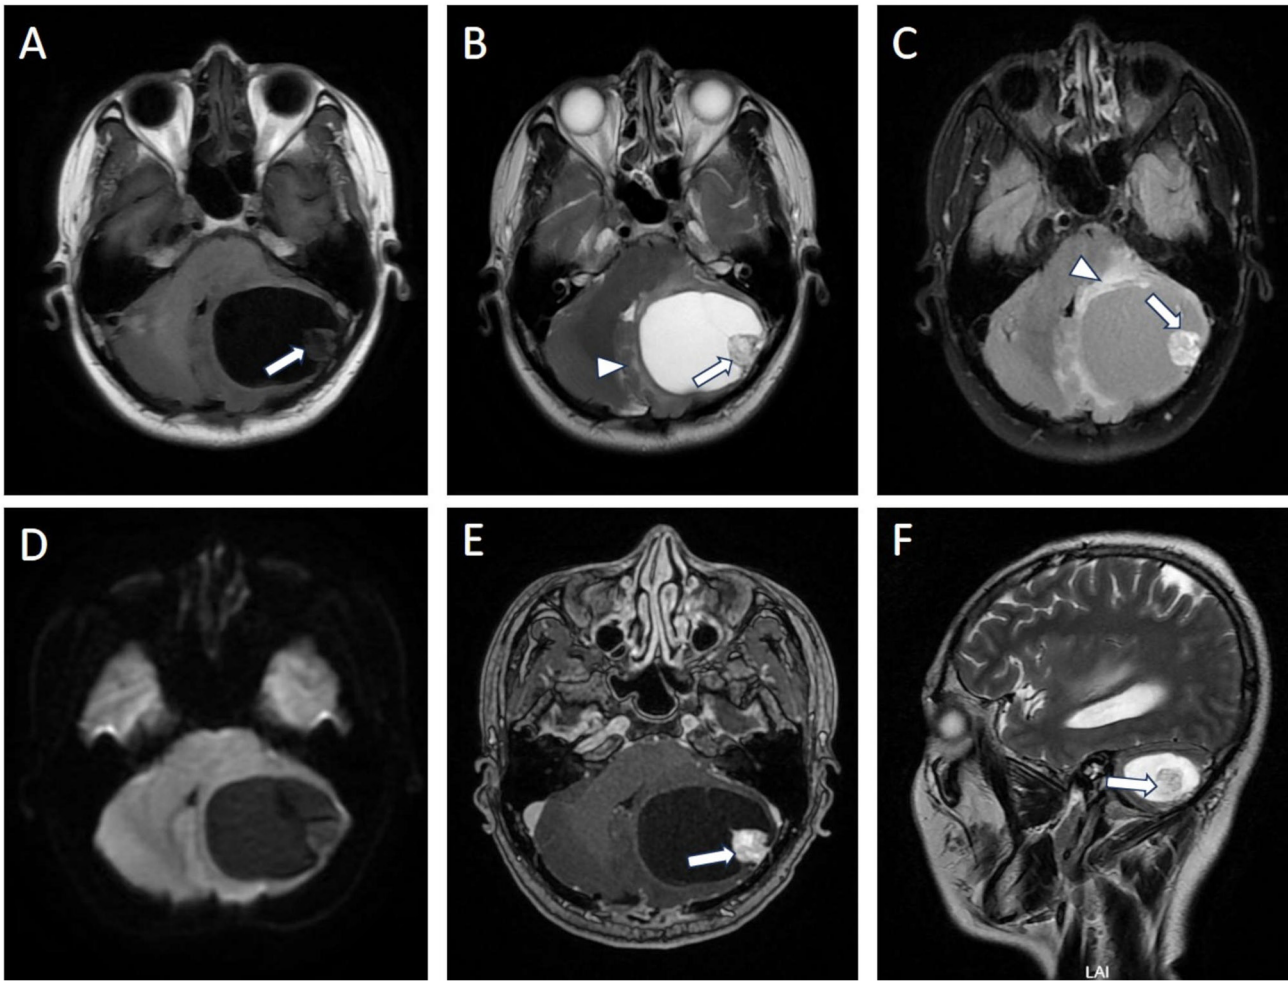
Preoperative MRI scans of the left cerebellar hemangioblastoma. (A) Axial T1-weighted image showing a hypointense cystic lesion in the left cerebellum. (B) Axial T2-weighted image demonstrating cystic hyperintensity in the cerebellar lesion with a posterolateral mural nodule. (C) T2-weighted fluid-attenuated inversion recovery image revealing perilesional edema. (D) Diffusion-weighted imaging indicated a lack of diffusion restriction. (E) Axial contrast-enhanced T1-weighted image showing marked enhancement of the mural nodule. (F) Sagittal T2-weighted image demonstrating the cystic lesion with a mural nodule. The lesion caused compression of the dorsolateral brainstem and effacement of the fourth ventricle. Arrows indicate the mural nodule, and arrowheads indicate perilesional edema.
